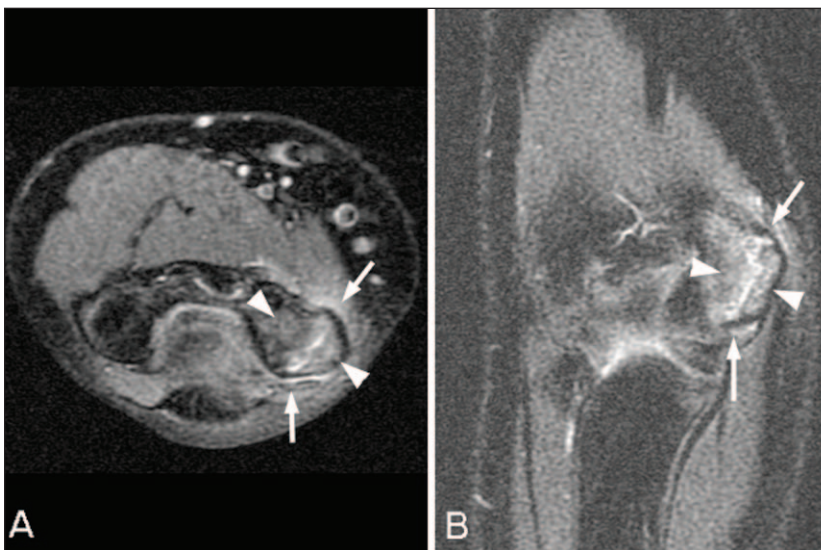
MRI of the right elbow including axial T2-weighted fat saturated (A) and coronal proton density fat saturated (B) images, showing increased signal (edema) within the medial epicondylar physis (linear high signal between the white arrows). Edema is also seen in the bone marrow of the condyle and epicondyle, adjacent to the physis (arrowheads).
